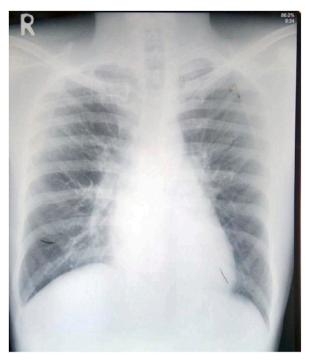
Chest X-ray evaluation after one-month treatment with the anti-tuberculosis drug.
